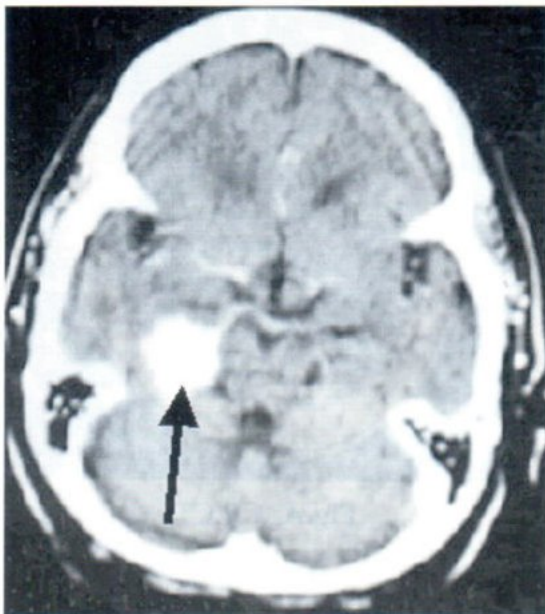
B Contrast enhancement CT. shows round opaque shadow at the posterior surface of Petrous ridge compatible with Meningioma.
